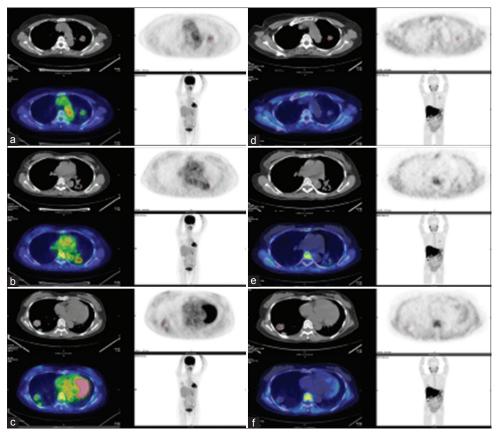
Whole-body [<sup>18</sup>F]-2'-fluoro-2'-deoxy-D-glucose positron emission tomography/computed tomography study (without contrast) in the same patient (Case 2) revealed multiple hypermetabolic pulmonary nodules in both lungs, suggestive of pulmonary metastases (a-c), which on the [<sup>18</sup>F]-fluorocholine positron emission tomography/noncontrast computed tomography study showed less uptake intensity in the corresponding lesions (d-f)
